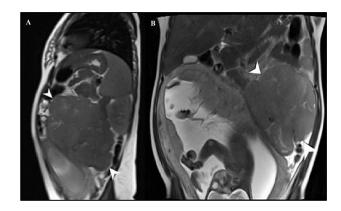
MRI scan done at 28 weeks of gestation showing solid soft tissue lesion. The arrows point to the solid soft-tissue lesion. (A) Sagittal MRI view showing a well-defined, multilobulated, solid soft tissue lesion. (B) Coronal MRI view of the lesion displacing the gravid uterus to the right. Abbreviation: MRI, magnetic resonance imaging.
